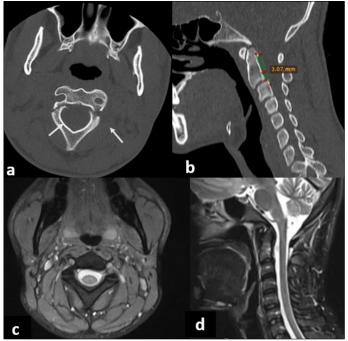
CT scan, bone window on axial (a) and sagittal (b, c) planes; and MRI, T2-weighted on axial (d) and sagittal (e) planes
